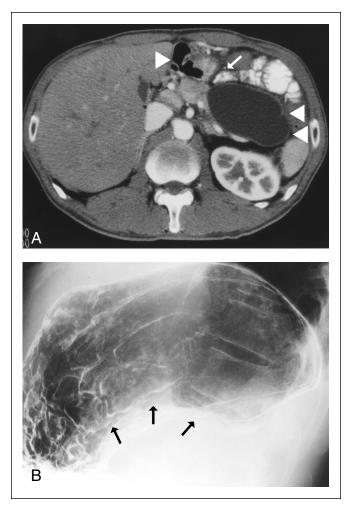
(A) Computed tomography of the abdomen demonstrates a cystic lesion in the tail of the pancreas and an intestinal structure (arrow) between the cyst (arrowheads) and the stomach (single short arrow). (B) An upper gastrointestinal series shows extramural compression along the greater curvature of the upper body of the stomach.
